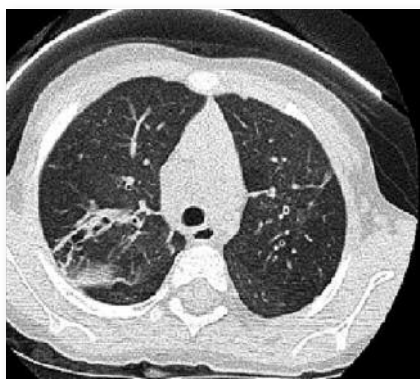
Case 3: high-resolution chest CT showing diffuse bronchiectasis in a child with immunodeficiency.
